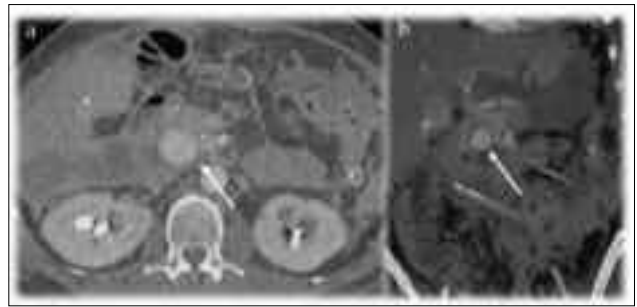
Pseudoaneurysm as a consequence of acute necrotizing pancreatitis. A – axial and B – coronal contrast-enhanced CT shows pseudoaneurysm that is feeding from gastroduodenal and superior mesenteric artery
